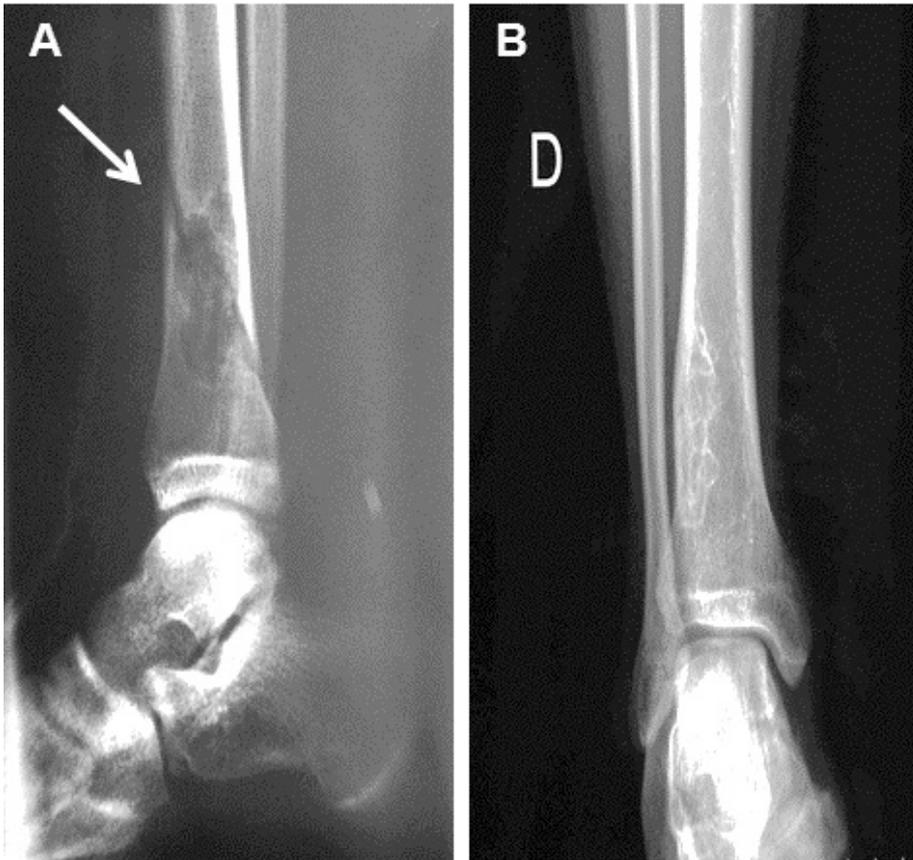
A and B - Lateral and anteroposterior X-rays of the ankle taken at the time of the fracture (patient was 17 years old). A radiolucent lesion with well defined and sclerotic borders with multilobular appearance can be observed in the distal diaphyseal-metaphyseal region of the tibia. A bowing of the inner surface of the tibia is observed. The image is compatible with ossifying fibroma. Tibial fracture line (arrow) was observed.
